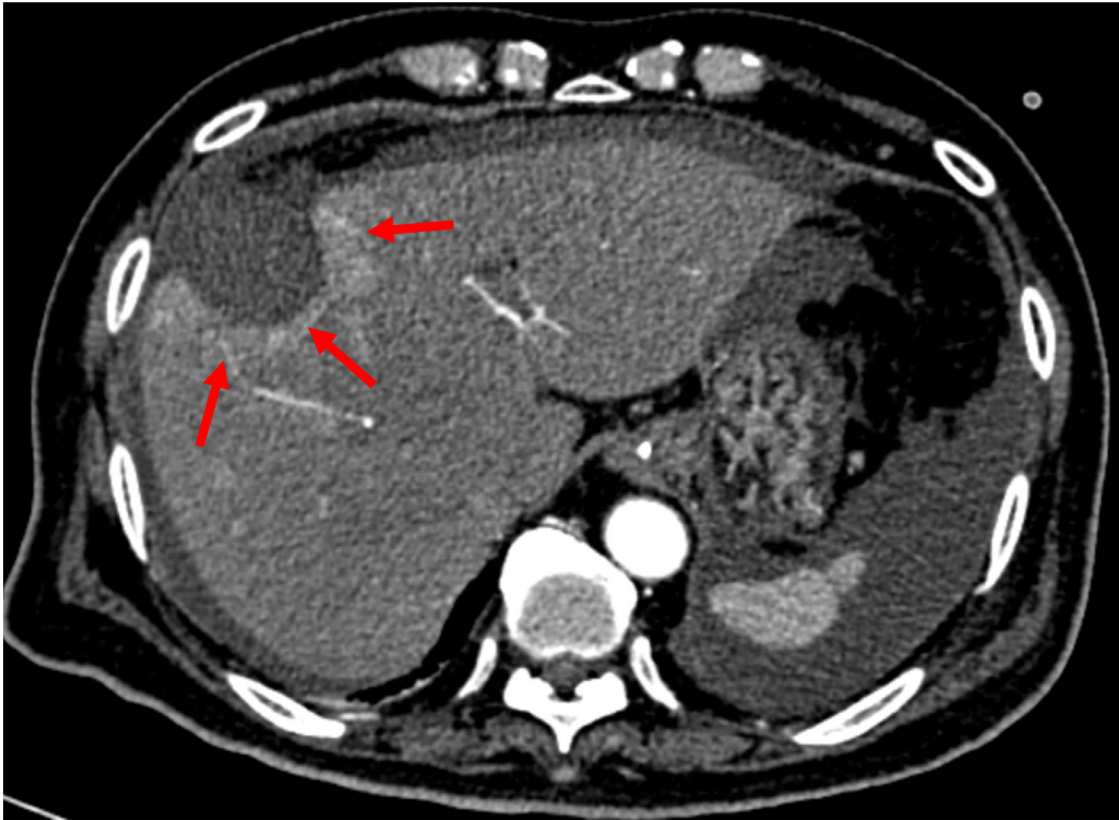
Axial CT scan through the gallbladder fossa in the arterial phase. Increased enhancement of the hepatic parenchyma of the gallbladder fossa (→) resulting from reactive hyperemia.
